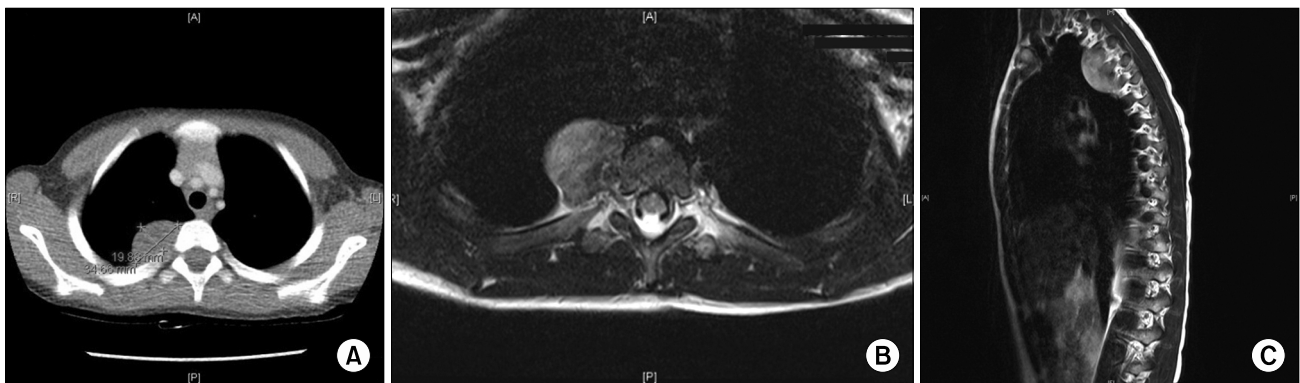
(A) Chest computed tomography showed a well-defined right posterior mediastinal mass measuring 4 cm. (B, C) Thoracic spine magnetic resonance imaging revealed a 4-cm right upper paravertebral enhancing mass lesion (T2–T5) with an adjacent neural foramina extension.
